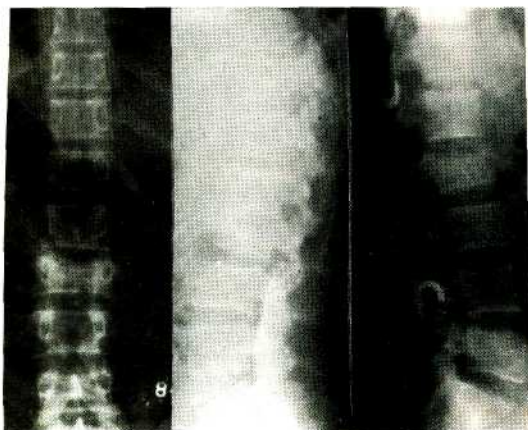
Pre and post-operative roentgenograms of a Burst type fracture, showing the reduction at L2 vertebra.
